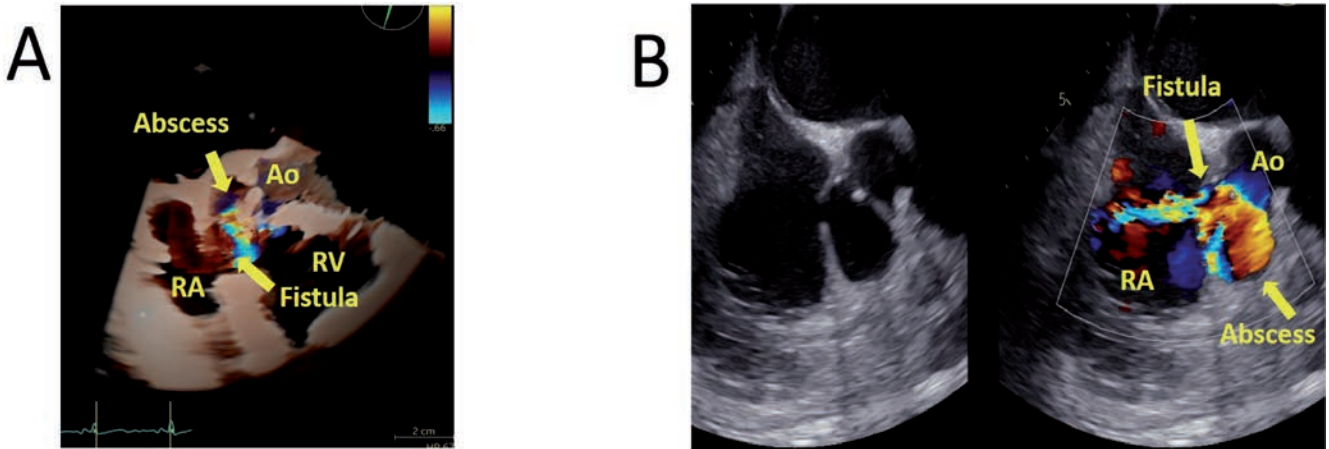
A) Long axis in transesophageal echocardiogram: turbulent flow through a fistula from the aortic abscess to the right atrium; B) 4 chambers: focus on the atria, which shows, at color Doppler, a turbulent flow from the aortic abscess to the right atrium. Ao, aorta; LV, left ventricle; RV, right ventricle; RA, right atrium.
